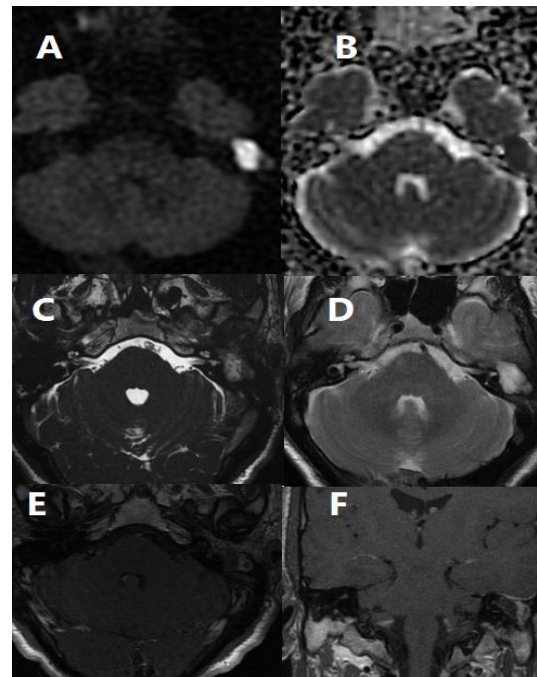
Selected MRI images that were typical for cholesteatoma: DWI (A). ADC (B). Axial T2 high-resolution (C). Axial T2 SE WI (D). Post-contrast axial T1 (E). Post-contrast coronal delayed T1WI (F). A left petrous bone abnormality, a bright DWI signal, a dark ADC signal (restricted diffusion), a bright T2 signal, and high-resolution T2 WI with marginal post-contrast enhancement in the delayed phase. Co-existing complication findings include infiltration of the facial nerve tympanic bony canal, tegmen tympani as well as dural enhancement are present. Intracranial extension does not exist.
